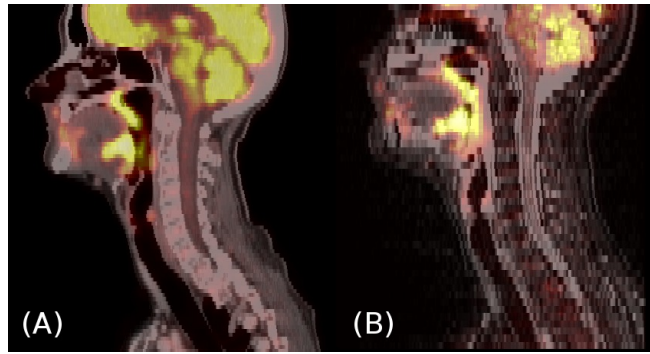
Dataset of Patient 1. (A) PET/CT, (B) PET/MR.
